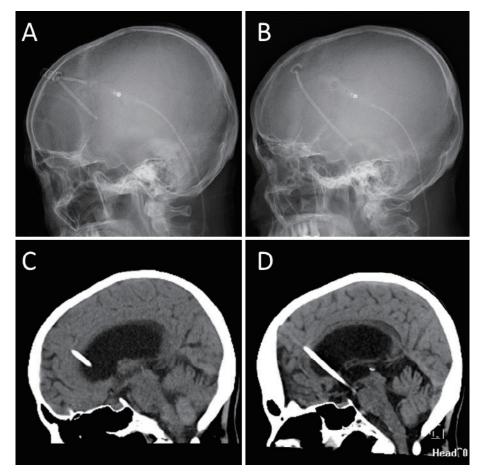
Lateral view of the head X-ray 1 year after the first surgery (A) and at the time of the present admission (B). Computed tomography of the right paramedian sagittal section 1 year after the first surgery (C) and at present admission (D).
